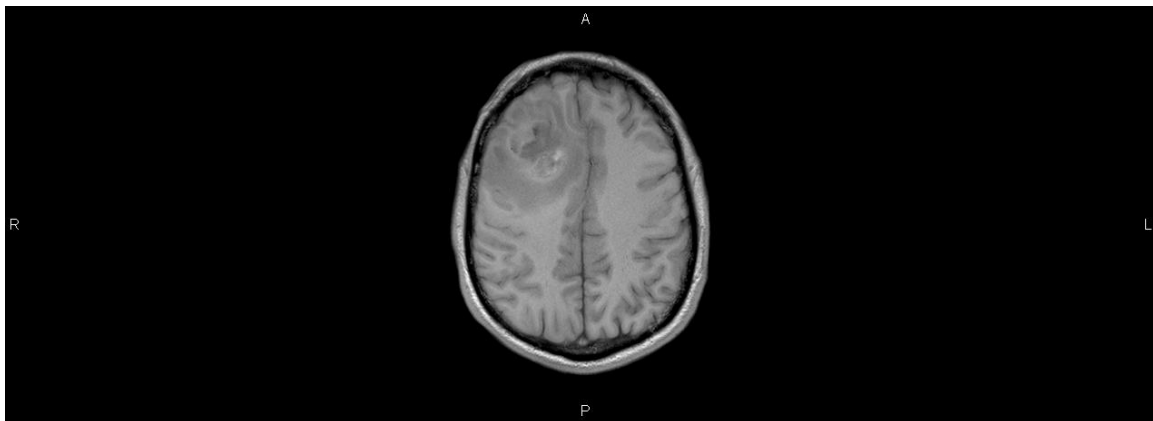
Axial T1W MRI. Heterogeneous mass in the right frontal lobe, demonstrating areas of high and low signal intensity and surrounding edema.
